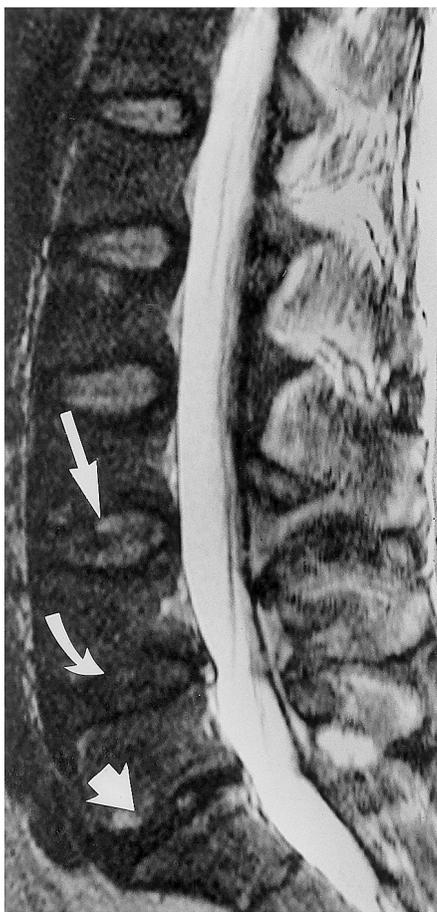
Grading of different levels of disk degeneration on T2-weighted MR image (6,000/105; FOV, 30 × 30; section thickness, 4 mm; matrix, 512 × 224). L1-2, L2-3, and L3-4 disks were graded 0; L3-4 disk with slightly blurred intranuclear cleft (thin arrow); L4-5 disk with decreased signal intensity was graded 1 (curved arrow); and L5-S1 disk with decreased signal intensity and height loss was graded 2 (thick arrow).
